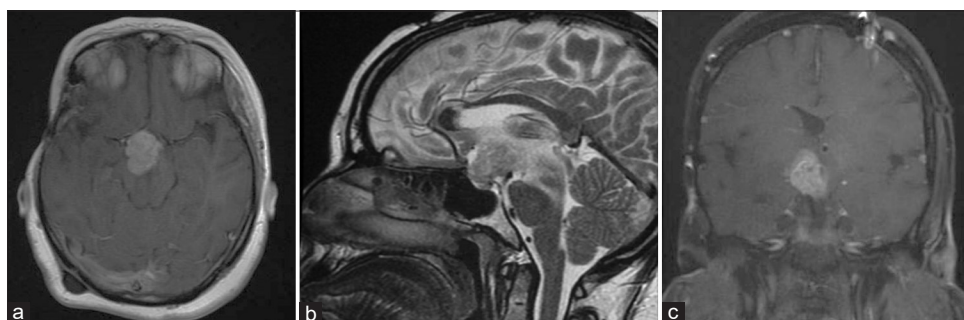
Repeat axial magnetic resonance imaging (MRI) with contrast in 2020 (a) and sagittal MRI T2 (b) and coronal MRI T1 with contrast (c) showing significant interval growth of the suprasellar mass occupying the anterior third ventricle and the interpeduncular cistern with evident mass effect on the surrounding neurovascular structures.
